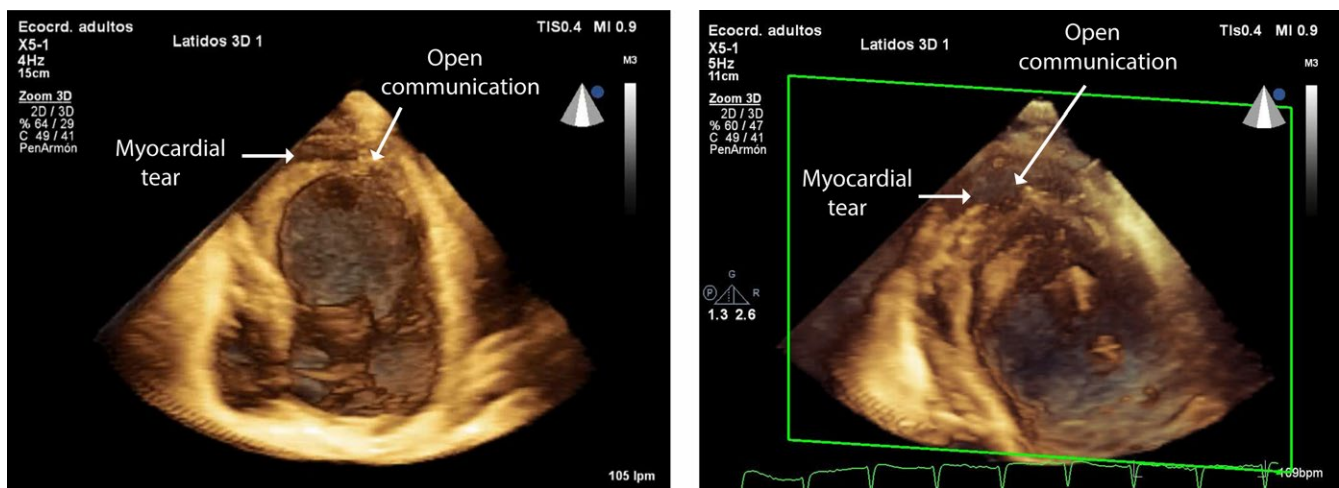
Three-dimensional transthoracic echocardiogram (3DTTE) showing myocardial tear dissecting the middle and distal portions of the anterior wall and the interventricular septum, with an open communication between the dissected portions and the pericardial cavity
